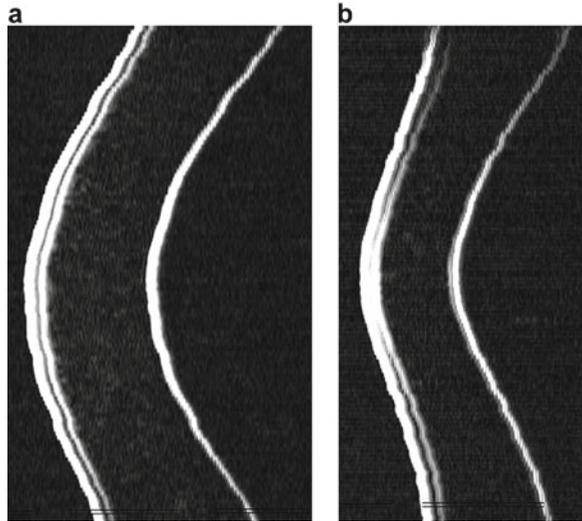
(a) (*left*) Horizontal non-geometrically corrected B-scan of a normal cornea obtained using the Artemis very high-frequency digital ultrasound arc scanner. The epithelium appears uniform in thickness across the 10 mm diameter of the scan. (b) (*right*) Vertical non-geometrically corrected B-scan of a keratoconic cornea obtained using the Artemis very high-frequency digital
